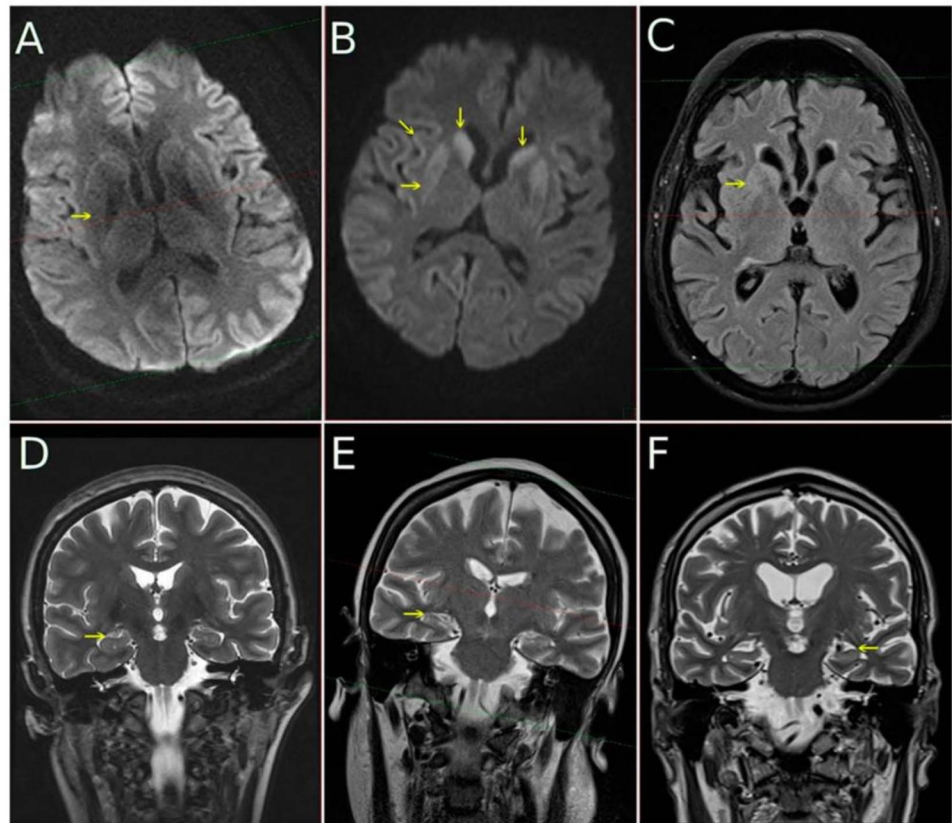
MRI in CJD subjects performed at 1.5T field strength: diffusion-weighted images ((A,B), DWI) with b-factor 1000, FLAIR image (C), coronal T2-weighted images (D–F). In the first column (A,D) data from subject with pure CJD—no DWI hyperintensity in putamina (arrow) is present and MTA is 0 (read as normal). In the second column (B,E) subject with tau comorbidity with mild hippocampal atrophy (MTA 1, arrow on (E)) and DWI (B) hyperintensity in putamina (horizontal arrow), caudates (vertical arrows) and with cortical ribboning (oblique arrow). In the third column (C,F) subject with CJD and AD comorbidity is shown. A moderate hyperintensity is visible not only on DWI (not shown), but as well on FLAIR image (C). Hippocampal atrophy is well pronounced, MTA 2 (arrow from right side of the (F), pointing to the left hippocampus which manifests clear atrophy).
